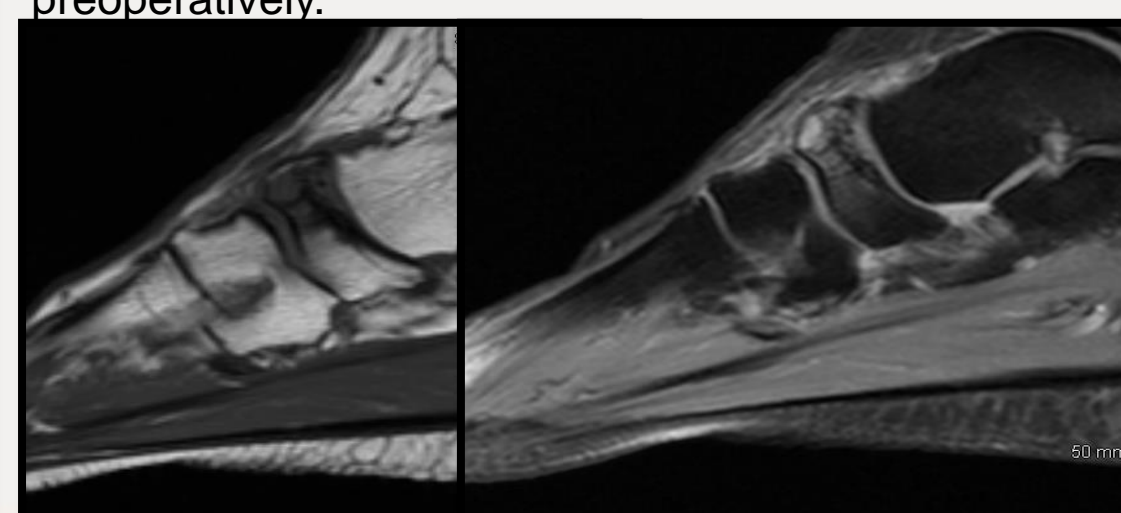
MRI reveals low signal intensity on T1 images and high signal intensity on T2 for intraosseous ganglion
